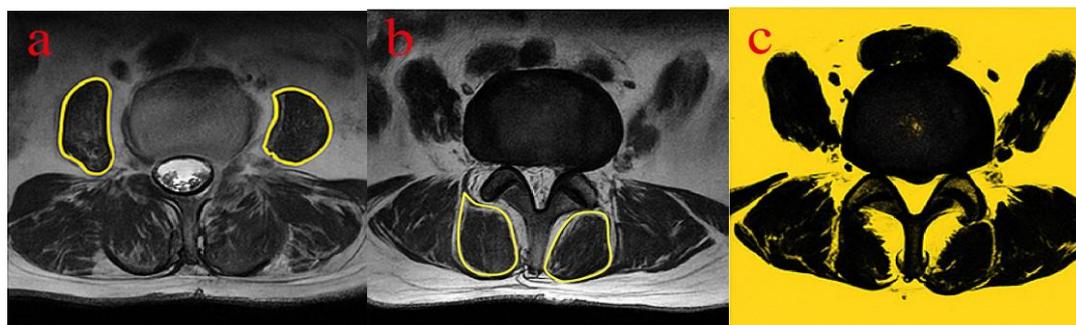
Measurement of psoas and multifidus muscles on lumbar spine MRI. a) CSA of the psoas muscle was manually traced at the upper endplate of the L3 vertebra on axial T2-weighted MRI. b) The CSA of the multifidus muscle was measured at the L4–5 and L5–S1 levels. c) Fat area within the multifidus muscle was visualized using a threshold-based pseudocoloring technique. PMF was calculated by subtracting the fat area from the total CSA and multiplying by 100 [11]
